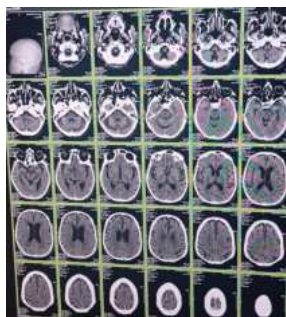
MRI Brain Showing Chronic Lacunar Infarct With Cerebral Atrophy And Microangiopathy
